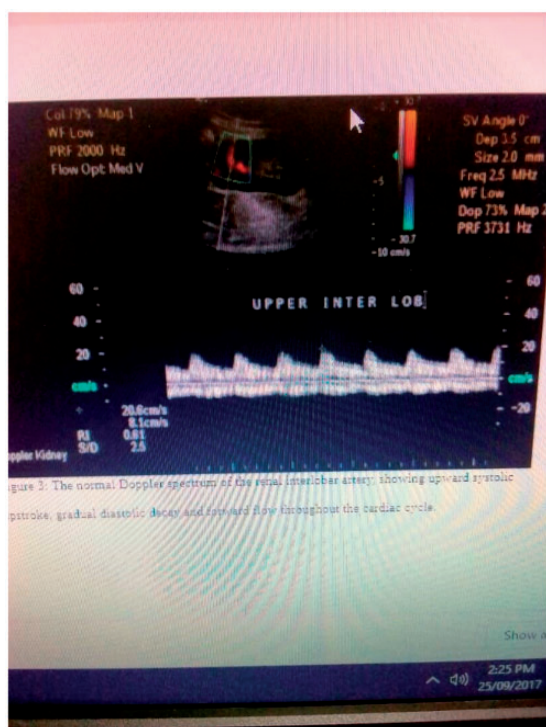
The normal Doppler spectrum of the renal interlobar artery, showing upward systolic upstroke, gradual diastolic decay, and forward flow throughout the cardiac cycle.
